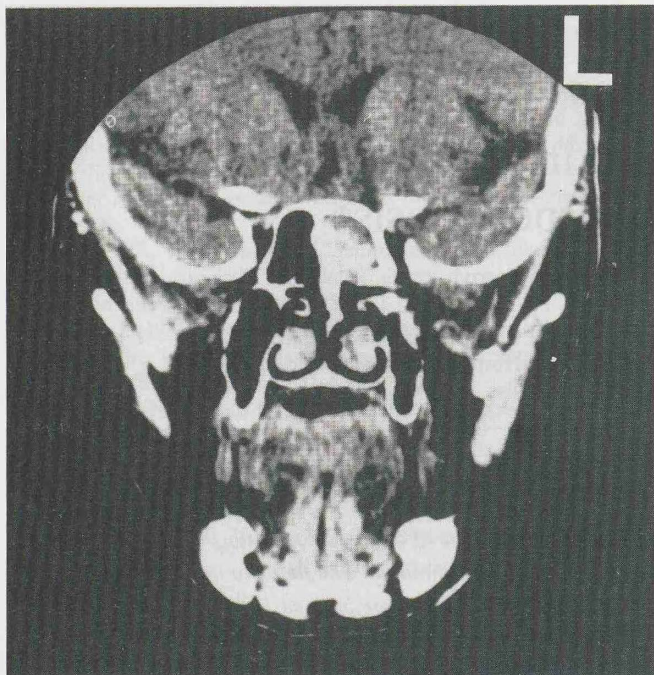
Coronal CT scan revealing complete opacification of the left sphenoid sinus with erosion of the floor. The sinus also contains radiopaque particles characteristic of *Aspergillus* concretions.
